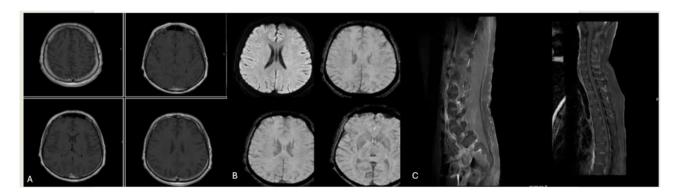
MRI brain, cervical, thoracic, lumber; Findings with contrast: MRI scans of the brain (A and B) and spinal cord (C) showed minimal enhancement of the cranial nerves and the anterior nerve rootlets of the cauda equina.
